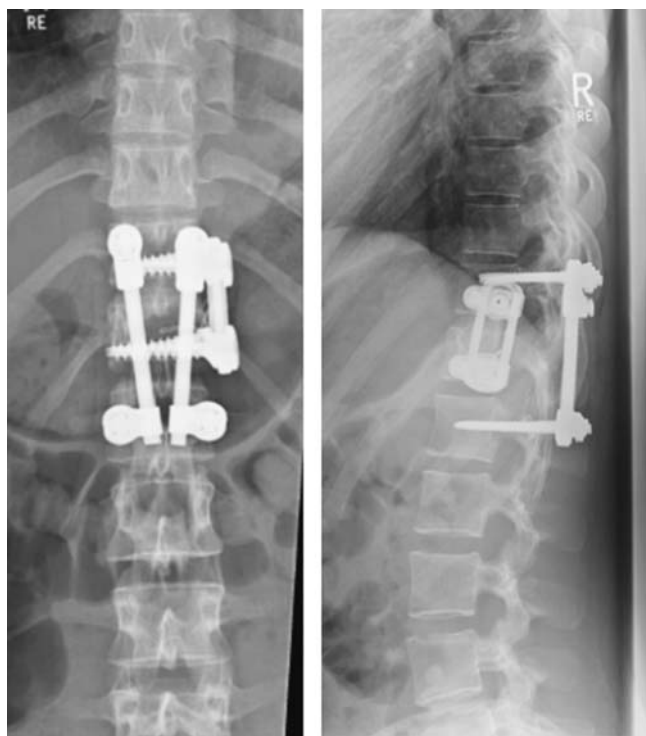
Postoperative X-ray check after initial dorsal bisegmental stabilisation and subsequent thoracoscopic monosegmental ventral fusion with the MACS TL system Th 11-12
